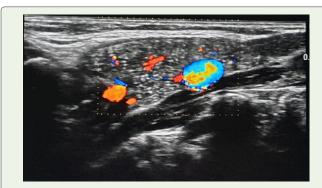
Ultrasonography of right side of neck showing normal echo pattern and vascularity in cervical ectopic thymus.
